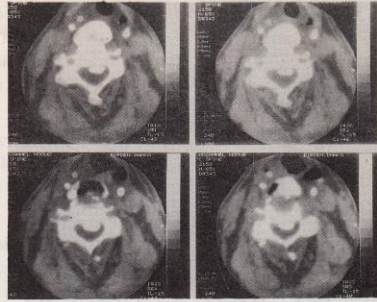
CT-scan at C3-C4 level : dense column of new bone enclosing a central hypodense zone anterior to vertebral column and a fracture on it; another dense-column of bone along the posterior longitudinal ligament.
